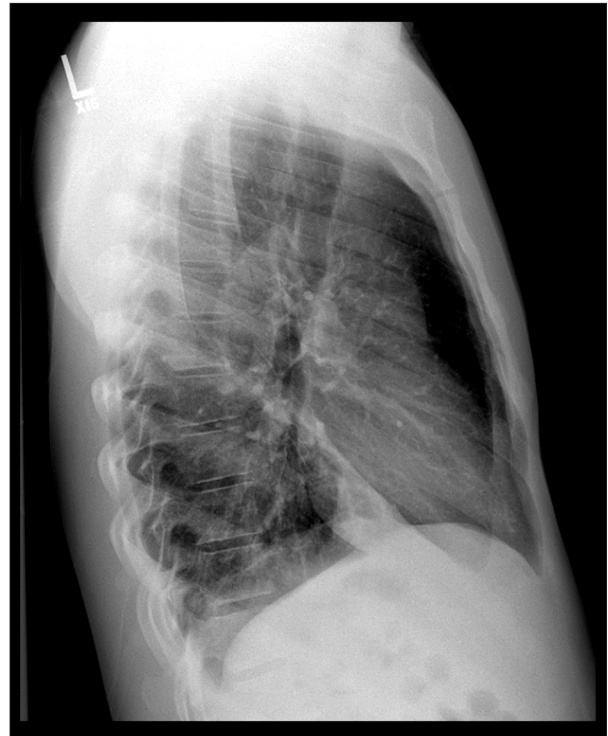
Chest radiograph on admission that demonstrates diffuse reticulo-nodular and interstitial infiltrates.
